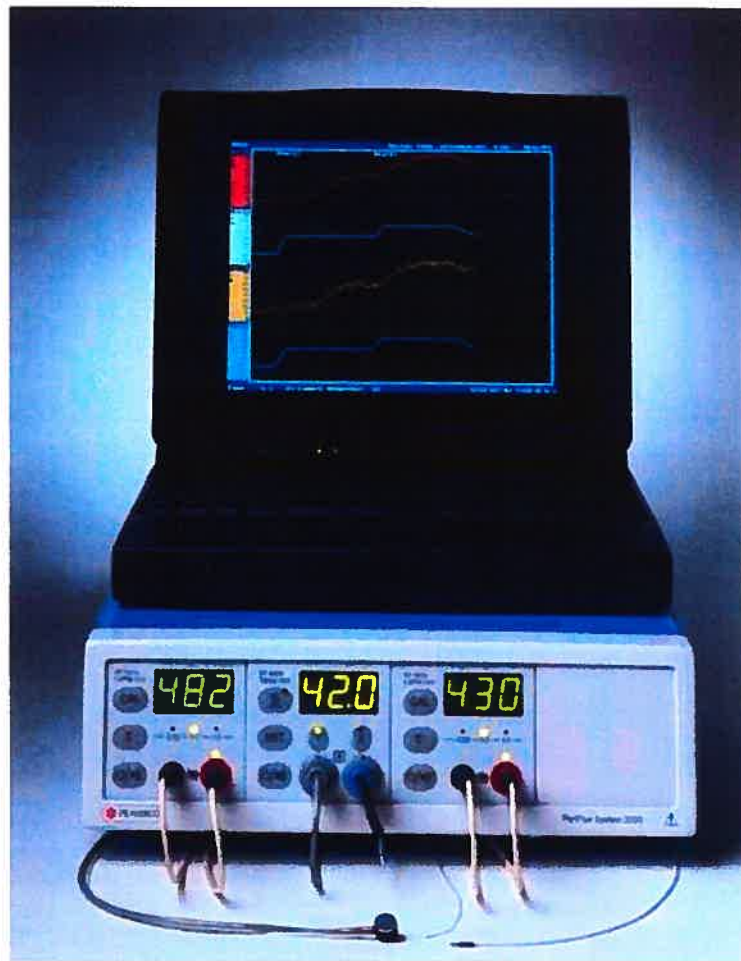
Laser-doppler apparatus
